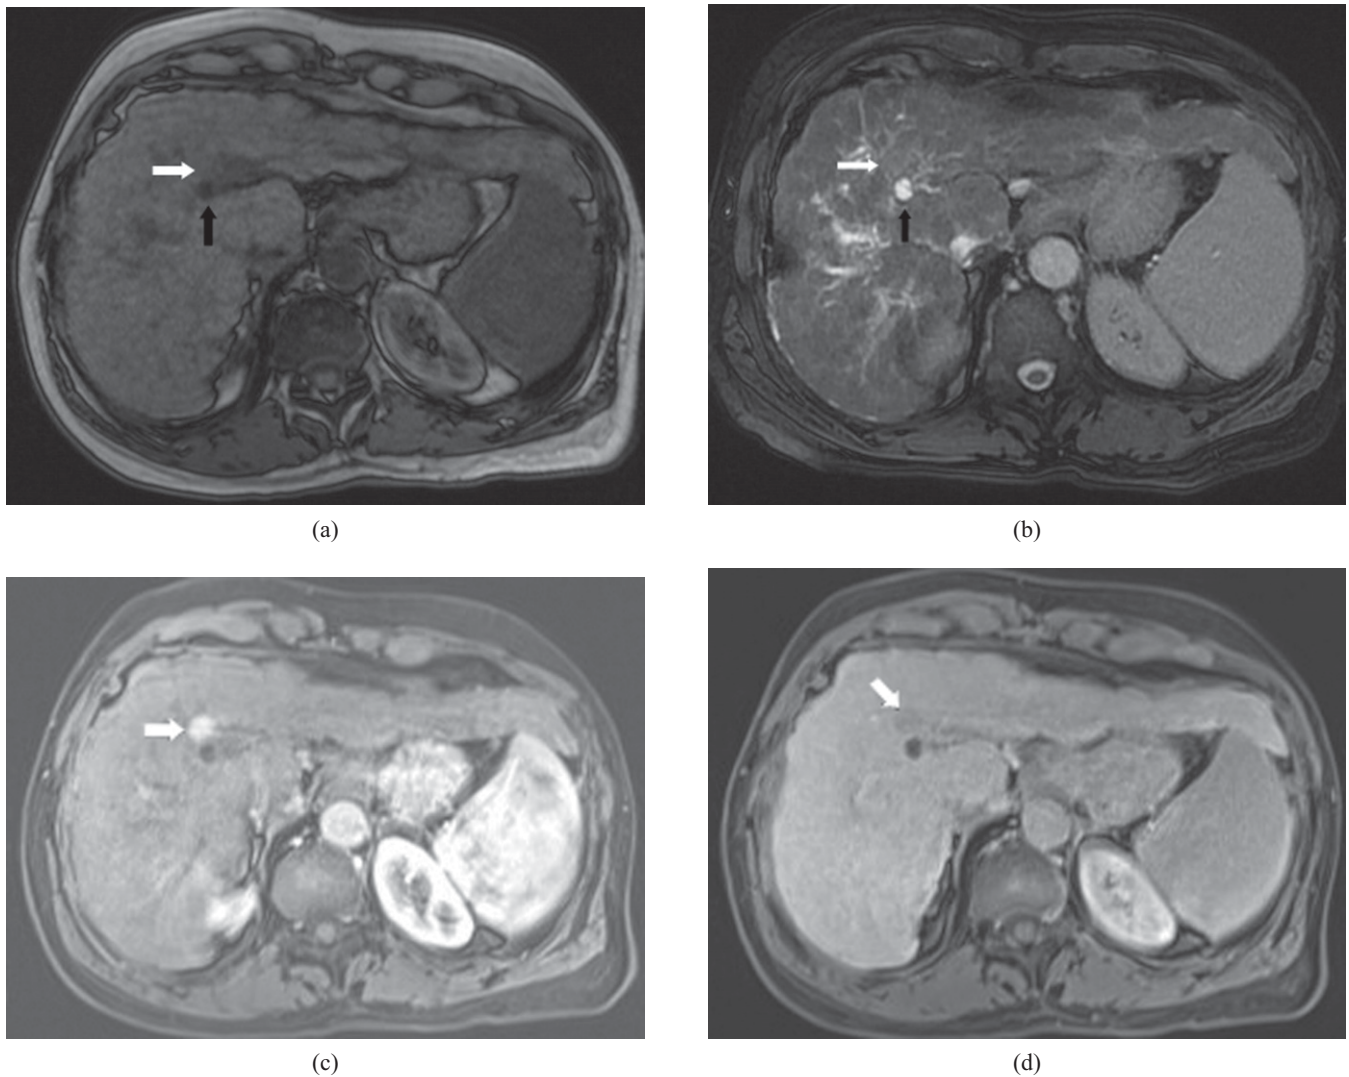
A 60-year-old man with hepatic cirrhosis secondary to viral hepatitis. MR images show established cirrhotic liver. Black arrows point to a simple cyst with simple fluid signal (axial T_1 weighted image (a) hypointense and (b) hyperintense on T_2 weighted image). White arrow points to hepatoma. This lesion is (a) mildly hypointense on T_1 and (b) mildly hyperintense on T_2 weighted images. Following dynamic post-contrast images with intravenous Primavist, the lesion shows arterial enhancement (c) and washes out on the delayed phase scan (d). The patient underwent radiofrequency ablation.
